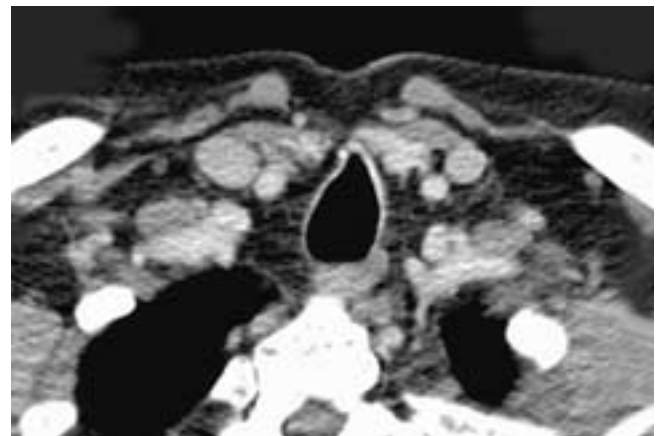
Axial contrast-enhanced CT scan shows a side-to-side collapse of the tracheal cross-sectional airway configuration due to injury of the tracheal cartilage from a prior tracheostomy.
